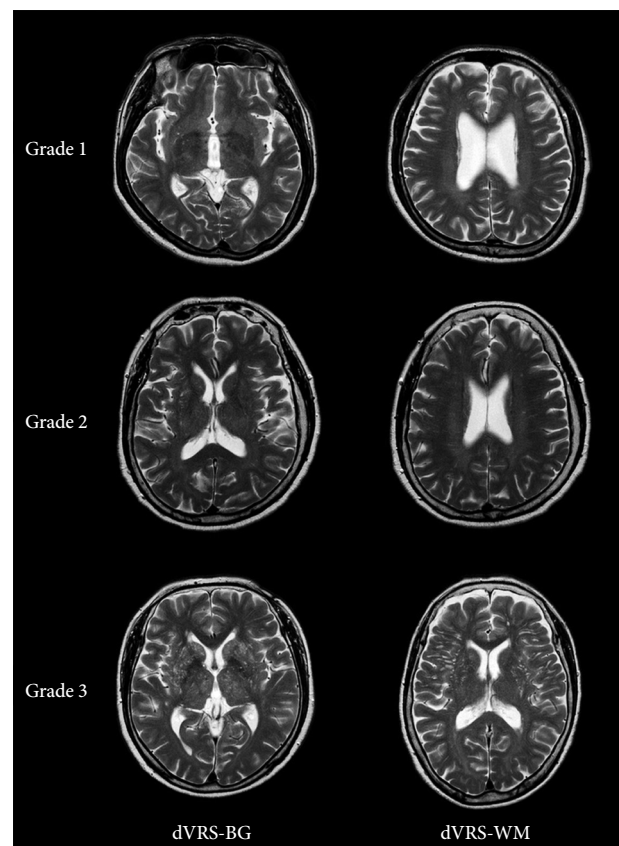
Representative MRI scans showing the severity of dilated Virchow-Robin spaces in the basal ganglia (dVRS-BG) and deep white matter (dVRS-WM).
